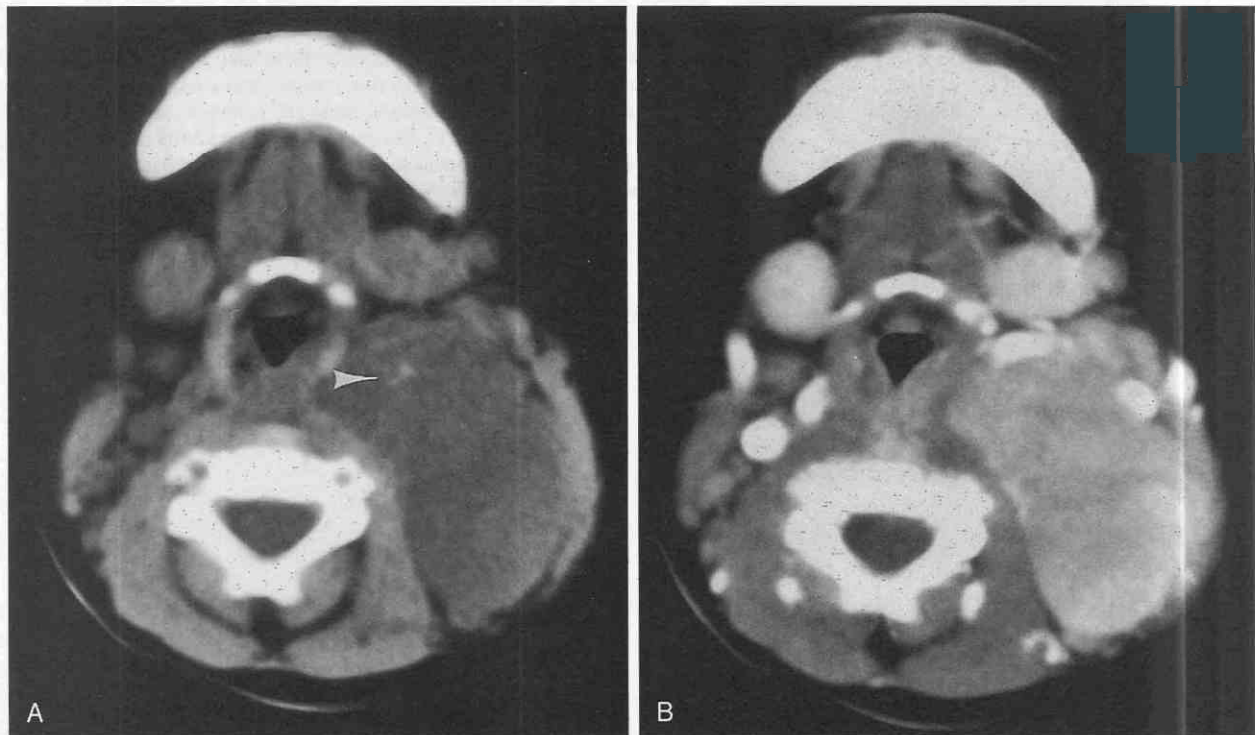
Cervical neuroblastoma. Axial precontrast (A) and postcontrast (B) CT scans. A, Small areas of calcification are seen (arrowhead) in a large mass of slightly decreased attenuation in the posterior triangle. B, There is moderate, homogeneous enhancement after contrast administration.
